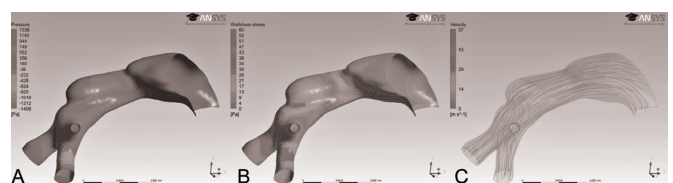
3D-CT Reconstruction analysis
